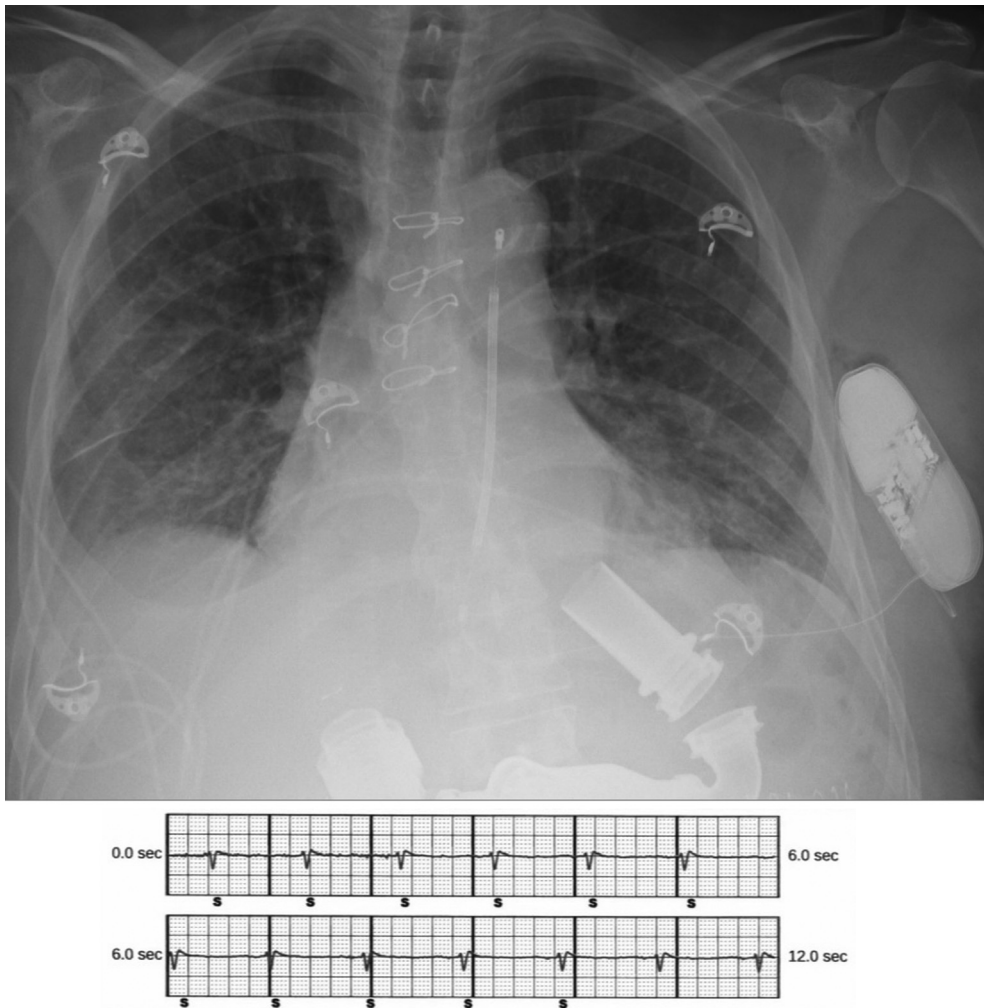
Chest radiograph showing implanted subcutaneous implantable cardioverter-defibrillator with HeartMate II (Abbott, North Chicago, IL) left ventricular assist device with associated alternate vector electrogram.
